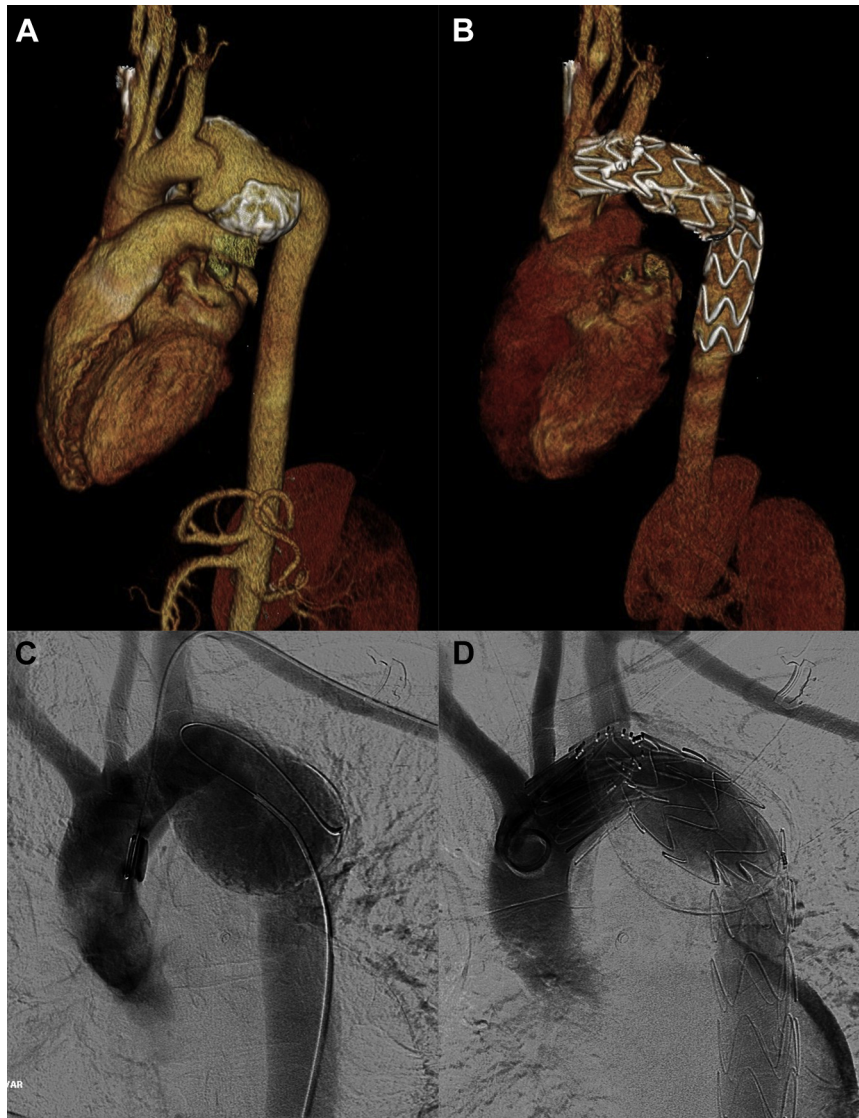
A and B, Three-dimensional reconstructions from computed tomography angiography of the aorta before and after (18 months) scalloped thoracic endovascular aortic repair (TEVAR). C and D, Images from digital subtraction angiography of the aortic arch before and after TEVAR with a scalloped endograft demonstrating isolation of the thoracic aortic aneurysm and patency of the left subclavian artery (LSCA).
